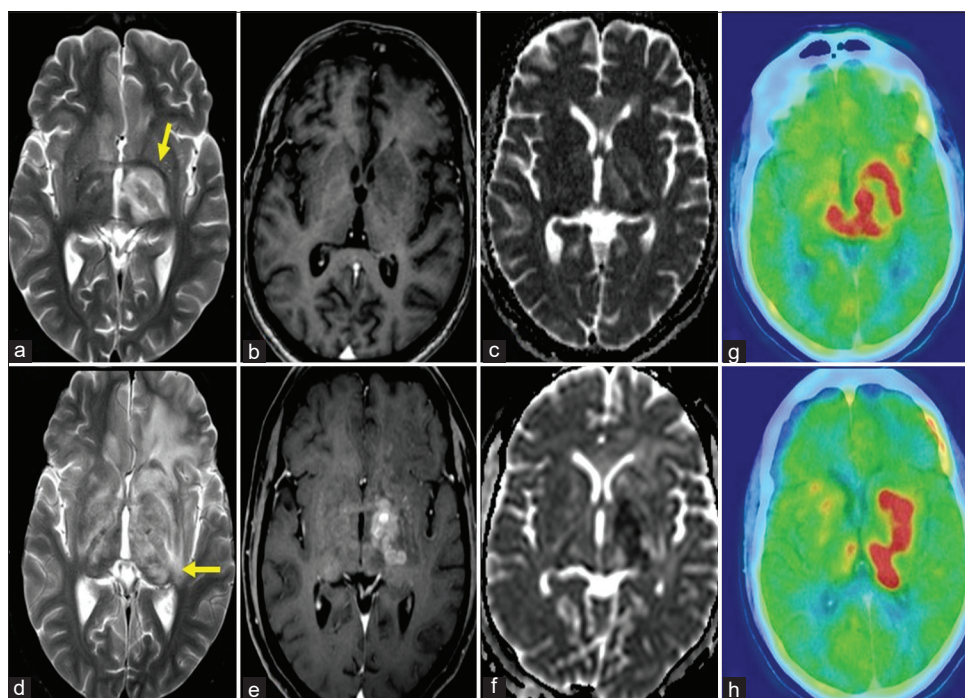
A 34-year-old male with lymphomatosis cerebri. Baseline axial T2W MRI (a) of the brain shows an intermediate to hyperintense lesion in left gray nuclei. There is no contrast enhancement (b), but areas of mild low ADC values are seen (c). Post-treatment MRI brain (d-h) shows disease progression in the form of extensive areas of disease involvement in bilateral deep gray and white matter, along with new areas of nodular and confluent enhancement (e) and low ADC values (f). PET-CT showed new areas of increased radiotracer activity (g and h). ADC: Apparent diffusion coefficient, PET-CT: Positron emission tomography-computed tomography.
